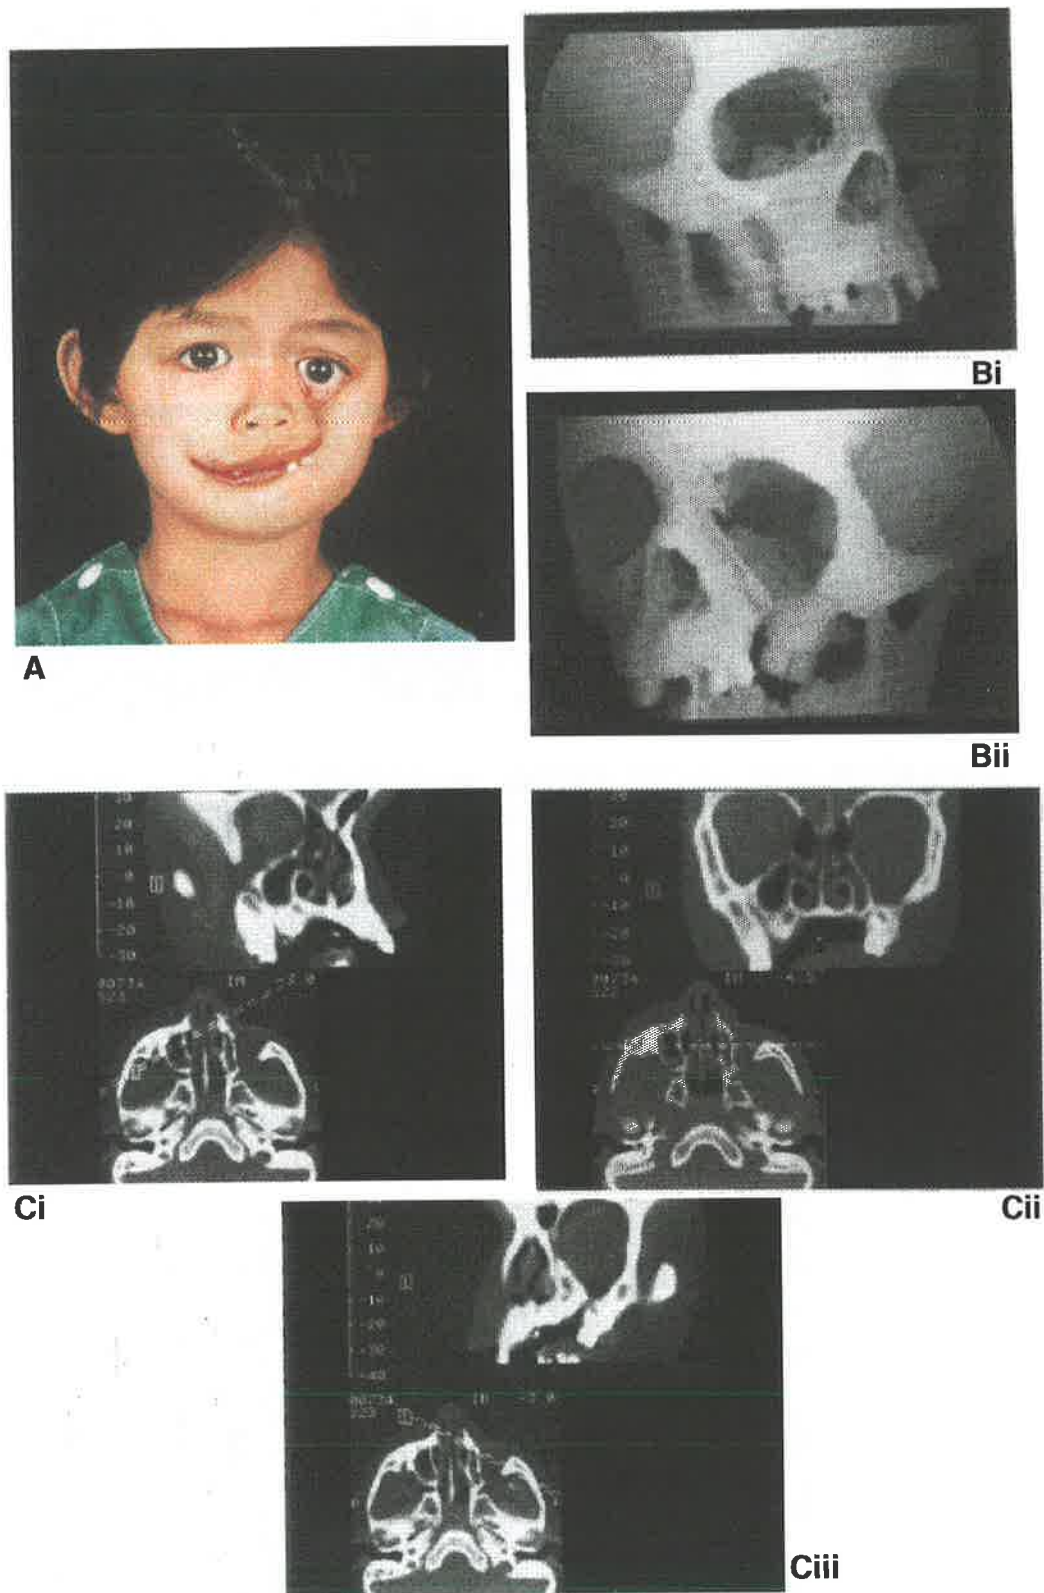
A. Five-year-old Malaysian boy with bilateral facial clefting of the Tessier Number 5 type, which is worse on the left side. B. Oblique three-dimensional CT reconstructions show the anterior boundaries of the bilateral Number 5 clefts from the premolar alveolar cleft below to the orbital floor above (i-ii). C. Oblique two-dimensional CT reformats demonstrate some of the techniques available for tracking the clefts posteriorly through the face (i-iii).
